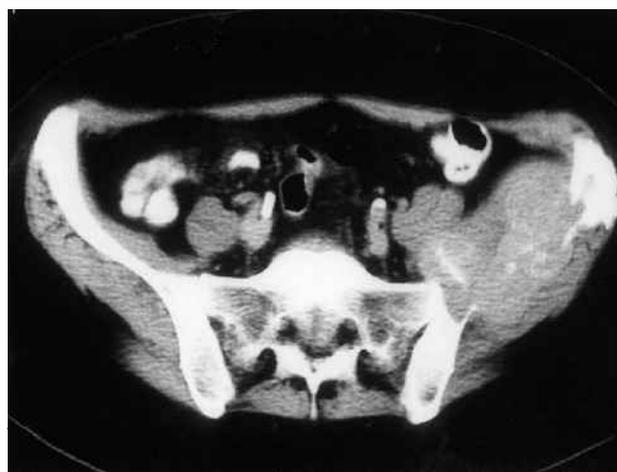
(A) Pretreatment computed tomography of pelvis showing large lytic bone destruction in the iliac area with substantial soft tissue component. (B) Post-treatment scan (approximately 6 months after chemotherapy and pamidronate) shows a decrease in soft tissue mass and partial reconstitution of iliac bone.
